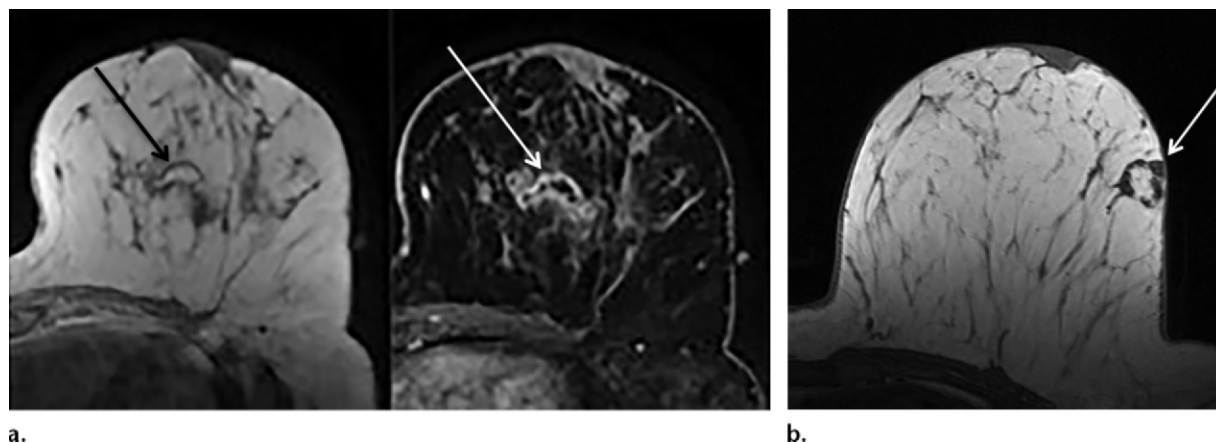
Fat-containing lesions. (a) Axial T1-weighted (left) and contrast-enhanced fat-saturated delayed (right) MR images show fat necrosis, characterized by findings of peripheral enhancement and central fat signal intensity (arrows). (b) Axial T1-weighted MR image shows a hamartoma (arrow), which was also fat containing on a mammogram (not shown).
